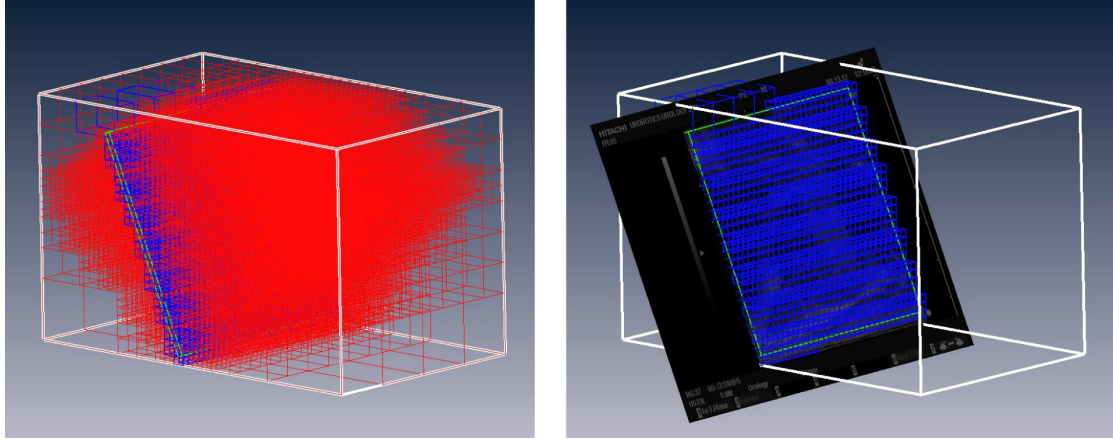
3D ultrasound image volume (white) divided into octree (red) for fast search.
